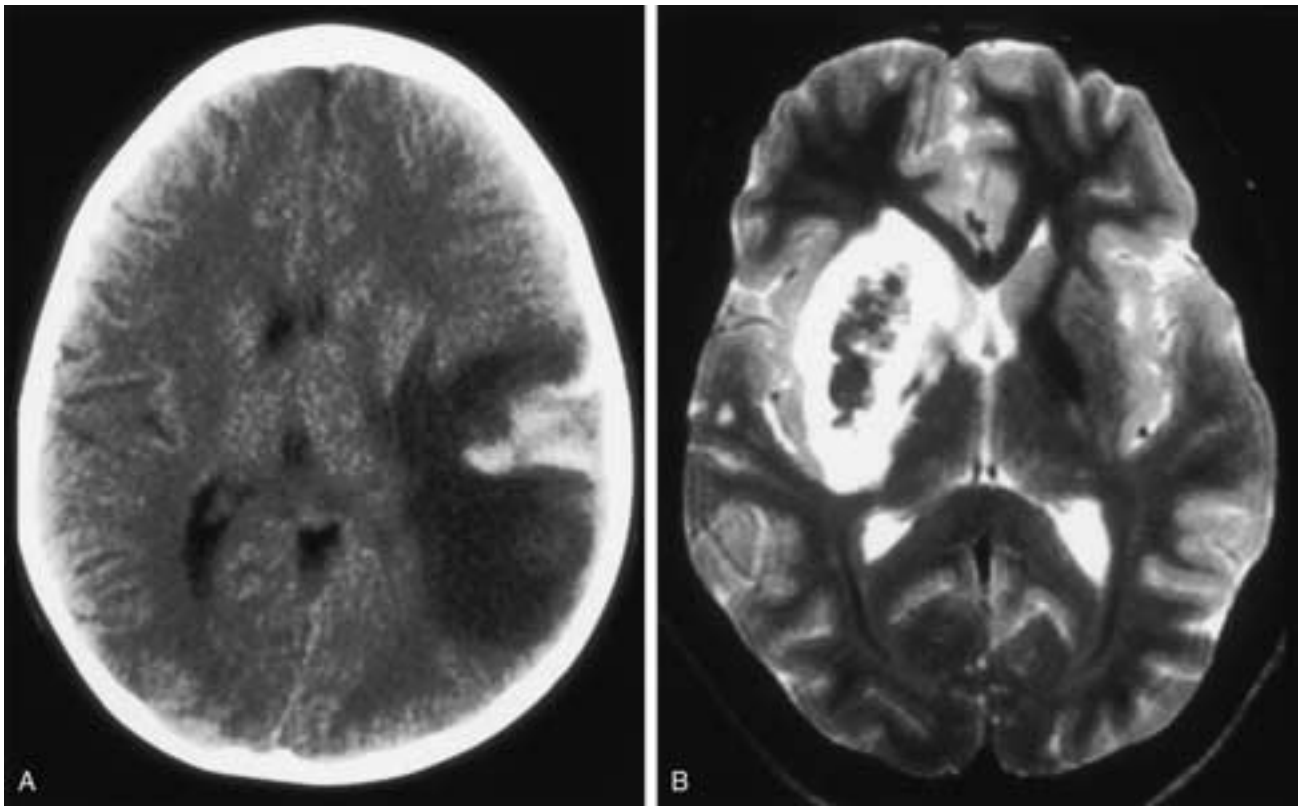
Hemorrhagic infarction. A, A 7-year-old female with cortical vein and transverse sinus thrombosis. Axial plain CT image shows a hypodense region in the left hemisphere with a central hyperdense hemorrhagic component. This hemorrhagic infarct causes a mass effect and a shift of midline structures to the right. B, A 15-year-old female with an embolic event. Axial T2-weighted MR image shows a right basal ganglionic region of both low (hemorrhage) and high (edema) signal intensity with mass effect.
